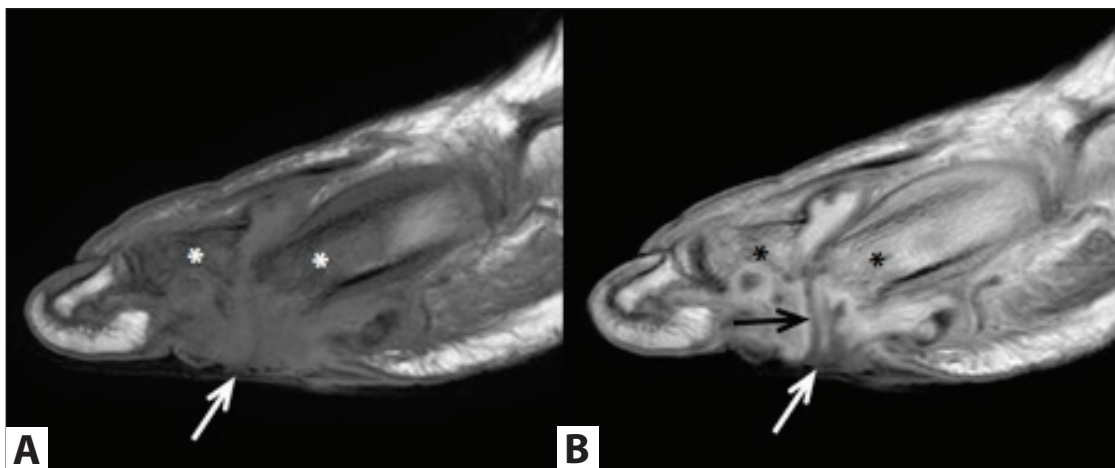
Skin ulcer (white arrows) on the plantar side of the first metatarsophalangeal joint on pre (A) and postcontrast (B) T1-weighted images in the sagittal plane, signal intensity changes consistent with osteomyelitis in the first metatarsal and proximal phalanx, and contrast enhancement (asterixes) and sinus tract extending into the joint space (black arrow) are observed.
